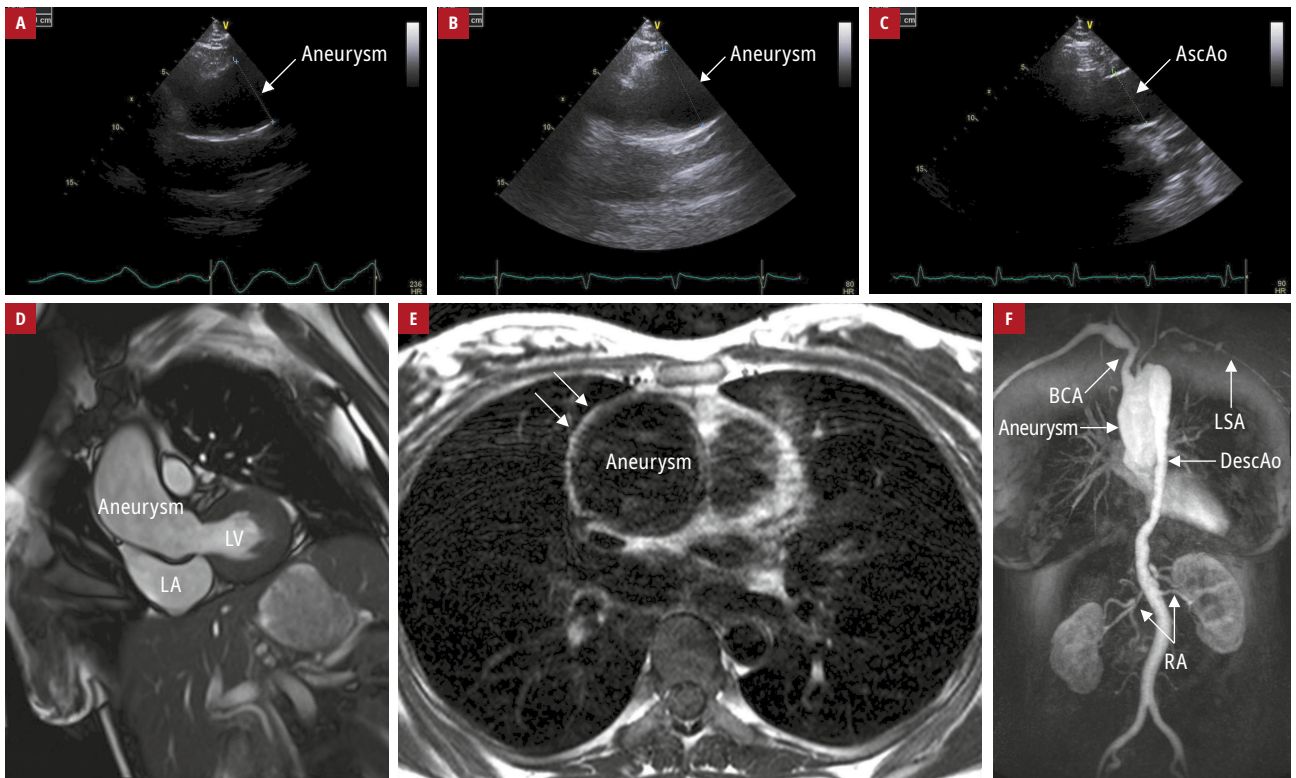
A – first transthoracic echocardiography showing an aneurysm (diameter, 49 mm) of the ascending aorta; B – second transthoracic echocardiography performed within 3 weeks and showing an enlarged aneurysm (diameter, 58 mm); C – postoperative transthoracic echocardiography showing the ascending aorta with a supracardiac vascular prosthesis (diameter, 41 mm); D – preoperative cardiac magnetic resonance (steady-state free precession) revealing the left ventricular outflow tract with an ascending aortic aneurysm; E – preoperative cardiac magnetic resonance (T1-weighted): a transverse section of the ascending aortic aneurysm with a thickened and fibrotic wall (arrows); F – preoperative cardiac magnetic resonance (magnetic resonance angiography with maximum intensity projection) showing the whole aorta and its branches with an ascending aortic aneurysm, narrowing of the descending aorta, and intact renal arteries
